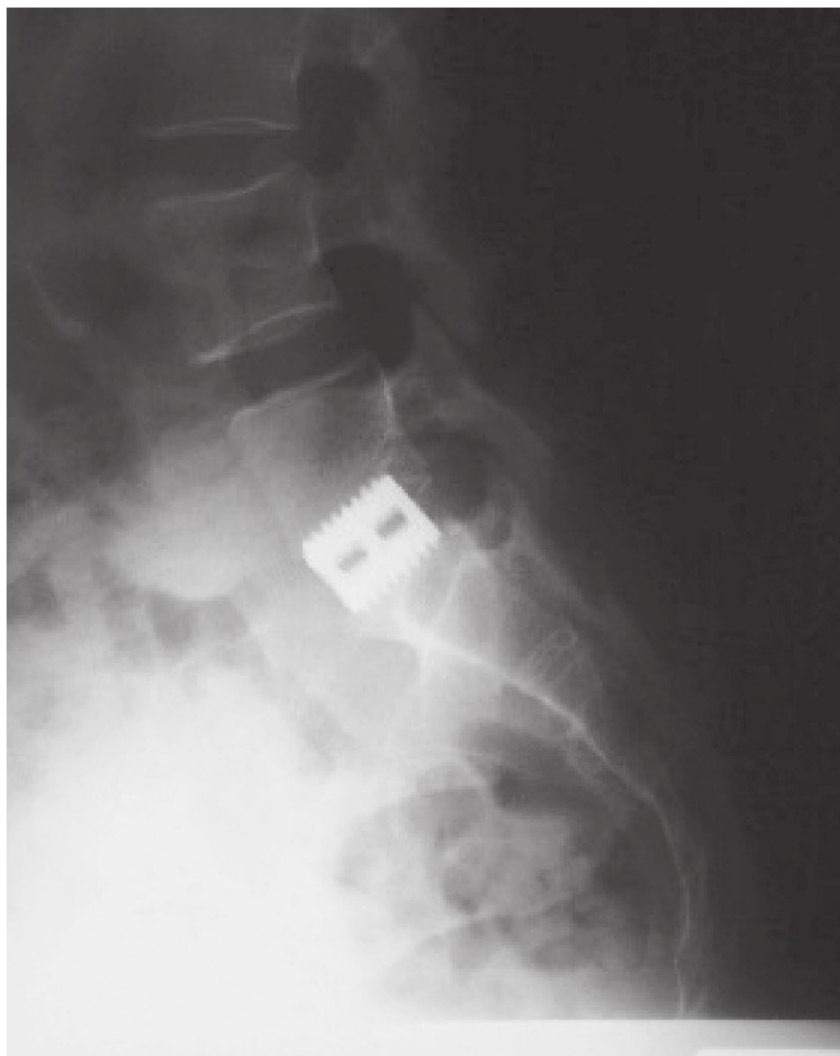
Postoperative lateral radiograph of an anterior IT Cage (Medtronic) at L5–S1.
